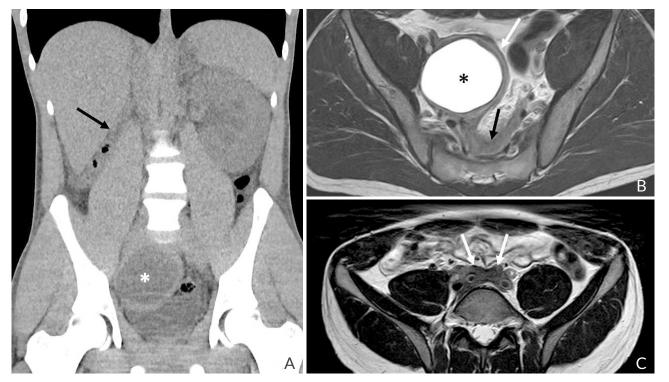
A) Coronal reconstruction of low-dose radiation CT showing the absence of the right kidney (black arrow) and a cystic lesion in the right hemipelvis (*). B) Axial T2-weighted image of the pelvis demonstrating a cystic lesion in the right hemipelvis, theoretically located in the seminal vesicle area. Its walls are thickened (white arrow), and a soft tissue component extending into the presacral region is observed (black arrow). C) Axial T2-weighted image of the pelvis (cranial to the anterior cut) identifying a soft tissue component (white arrows) surrounding the common iliac vessels.
